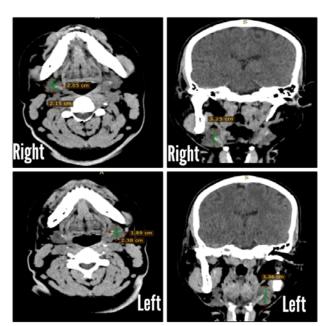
Measurements of the bilateral Submandibular Salivary Gland in Axial, Transverse and Cranio-caudal Dimensions using Computed Tomography
